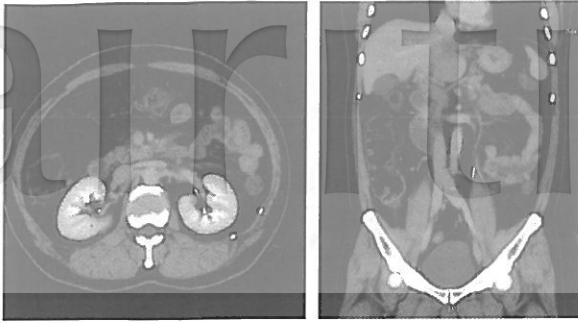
Day1 Computed tomography (CT) of the abdomen, with administration of contrast materials, showed thromboses of portal veins, main portal vein, splenic vein and proximal superior mesenteric vein.
